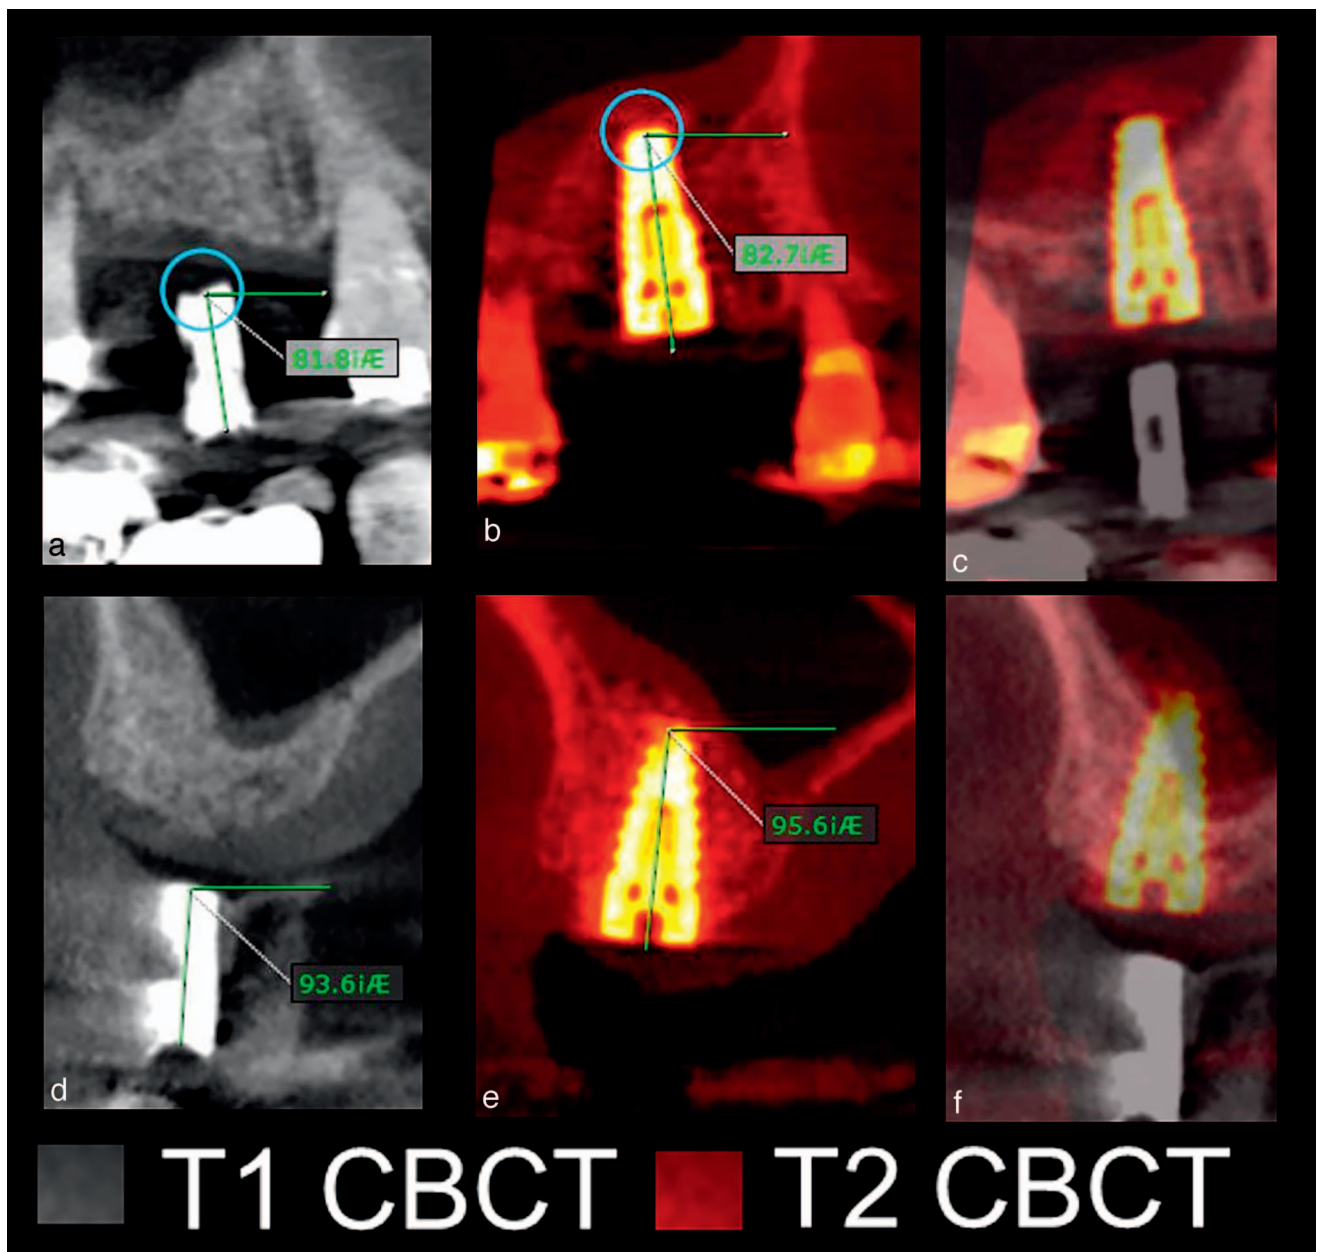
(a) T1 sagittal slice showing implant guide angulation. (b) T2 sagittal slice showing implant angulation. (c) T1 (gray) and T2 (red) slices superimposed showing the angulation of the planned treatment and final outcome. (d) T1 coronal slice showing implant guide angulation. (e) T2 coronal slice showing implant angulation. (f) T1 (gray) and T2 (red) slices superimposed showing the angulation of the planned treatment and final outcome. All the slices have the same orientation. CBCT indicates cone-beam computerized tomography.
